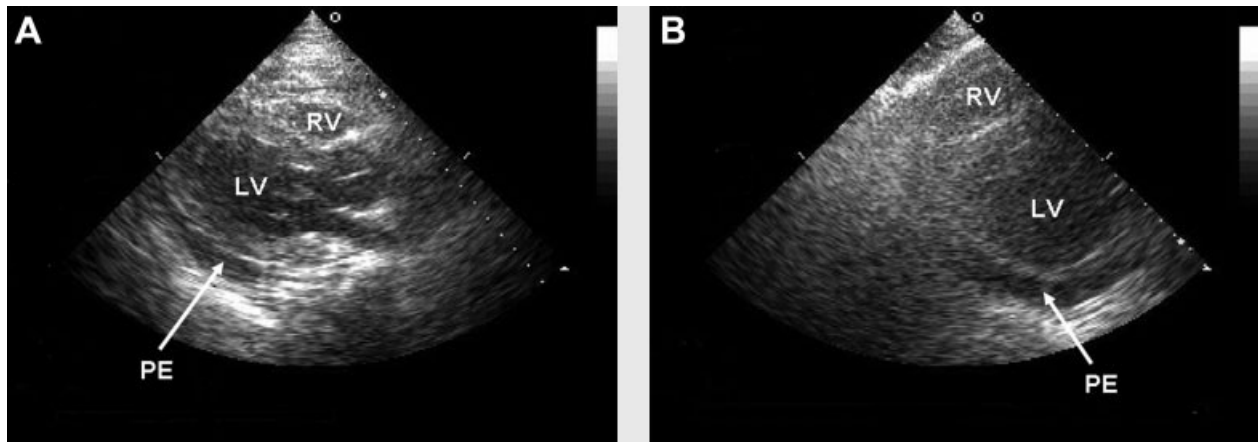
(A) Echocardiography from long-axial view showed a small pericardial effusion in the posterior of left ventricle. PE, pericardial effusion; RV, right ventricle; LV, left ventricle. (B) Echocardiography from subxiphoid view show a small pericardial effusion in the lateral sides of left ventricle.
